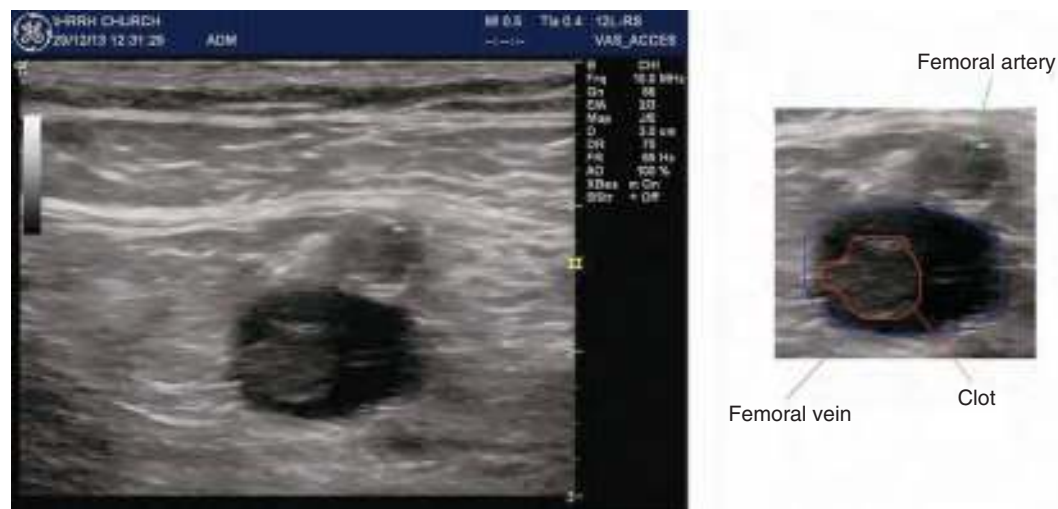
Ultrasound of a femoral deep venous thrombosis. (Photo courtesy of Lloyd Gordon, MD.)
